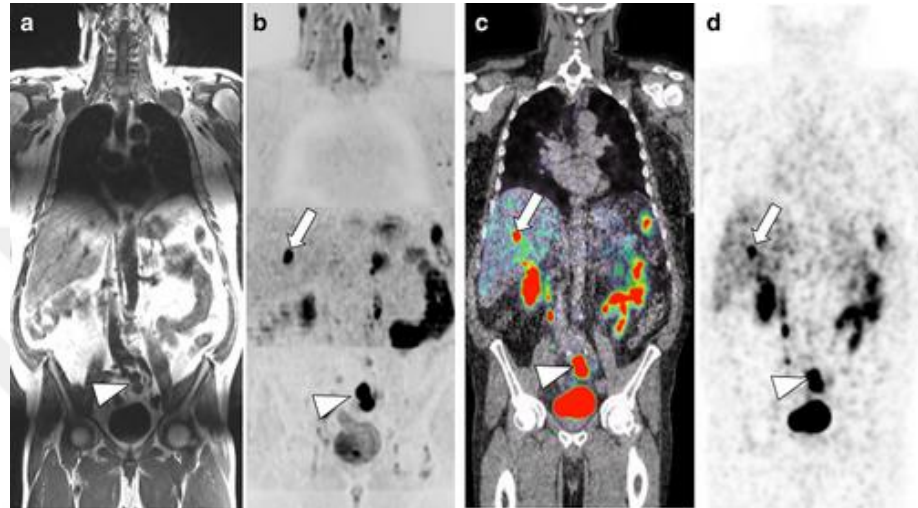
Whole body magnetic resonance imaging (WB-MRI) and PSMA (Prostate Specific Membrane Antigen) PET/CT images of a 68-year-old man with stage IV prostate cancer. (a,b) Coronal WB-MRI (Whole Body MRI), (a) T1 TSE (Turbo Spin-Echo), (b) Coronal reformatted inverse grayscale DWIBS images show liver metastasis (arrow) lymph node metastasis (arrow). (c,d) 68 Ga-PSMA-PET/CT (68 Ga labeled Prostate Specific Membrane Antigen Positron Emission Tomography) images show liver metastasis (arrow) lymph node metastasis (arrow) (Van Nieuwenhove, S., et al., 2022).
